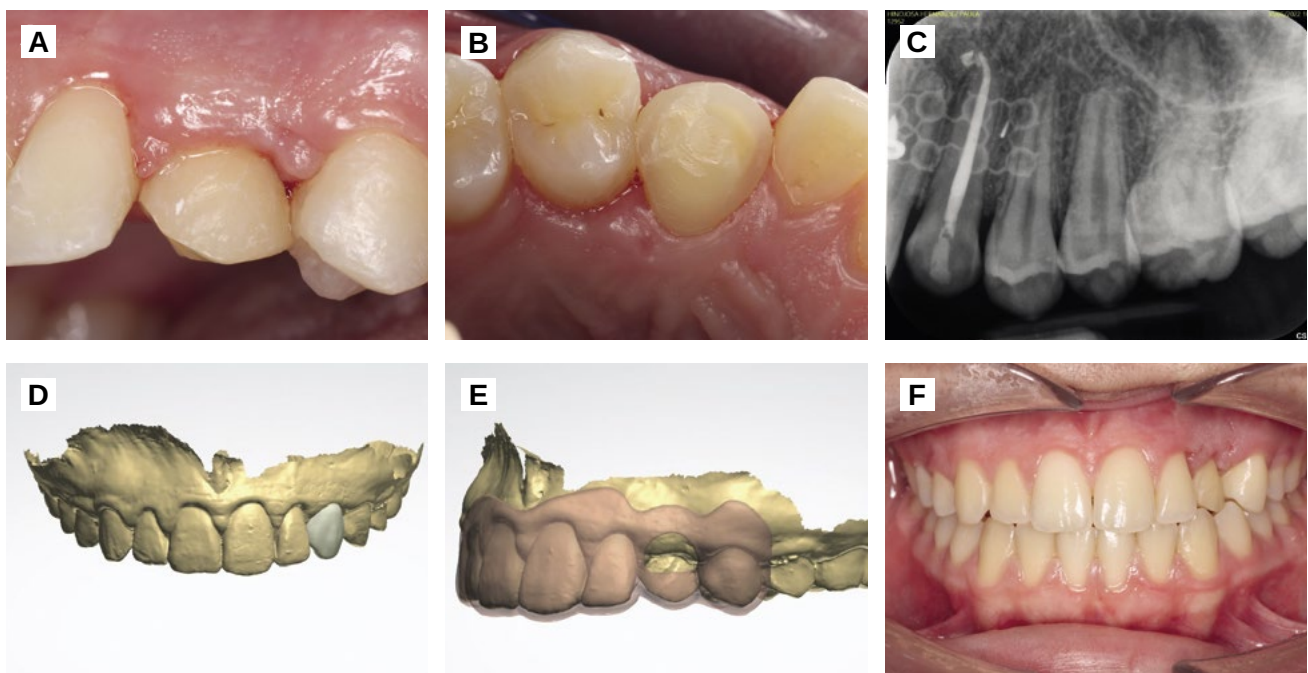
A. Vestibular view of the orthodontic removal day 1 year after surgery. B. Occlusal view. C. Periapical radiography. D. Digital waxing. E. Digital preparation of guided splint for crown elongation. F. Post crown elongation.
